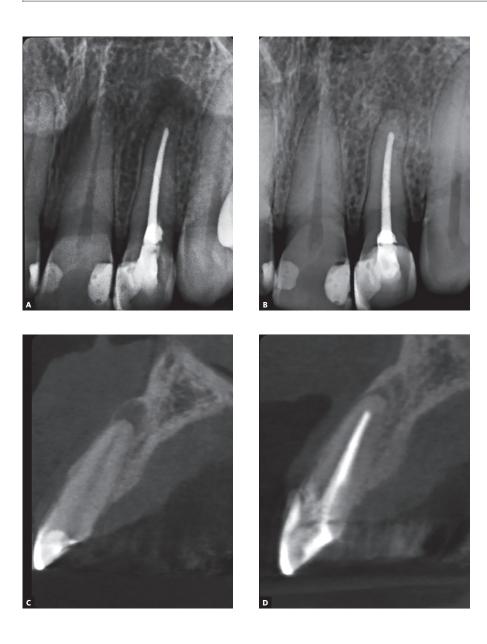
Image exams presenting bone neoformation in the periapical region of the tooth 22. A and B) Initial and final radiographic images. C and D) Initial and final tomographic images in longitudinal section.
